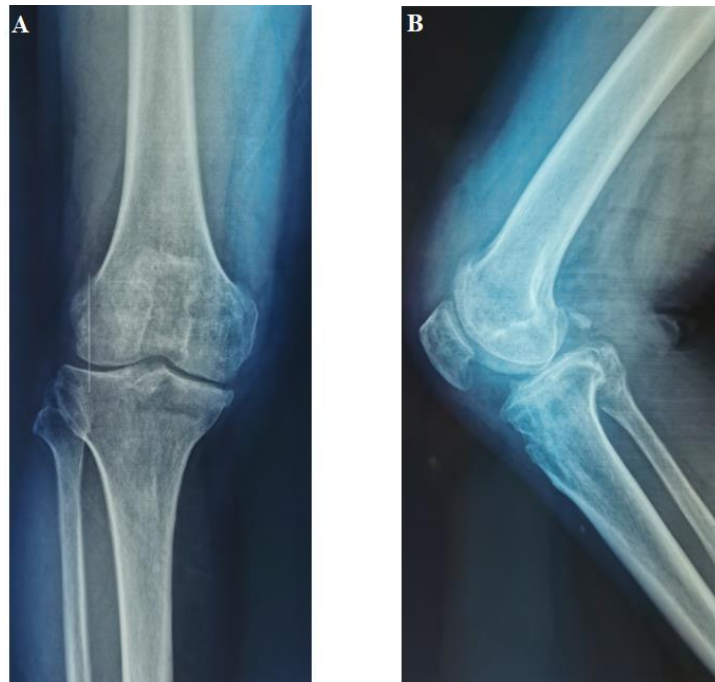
Follow-up radiography three months postoperatively.
